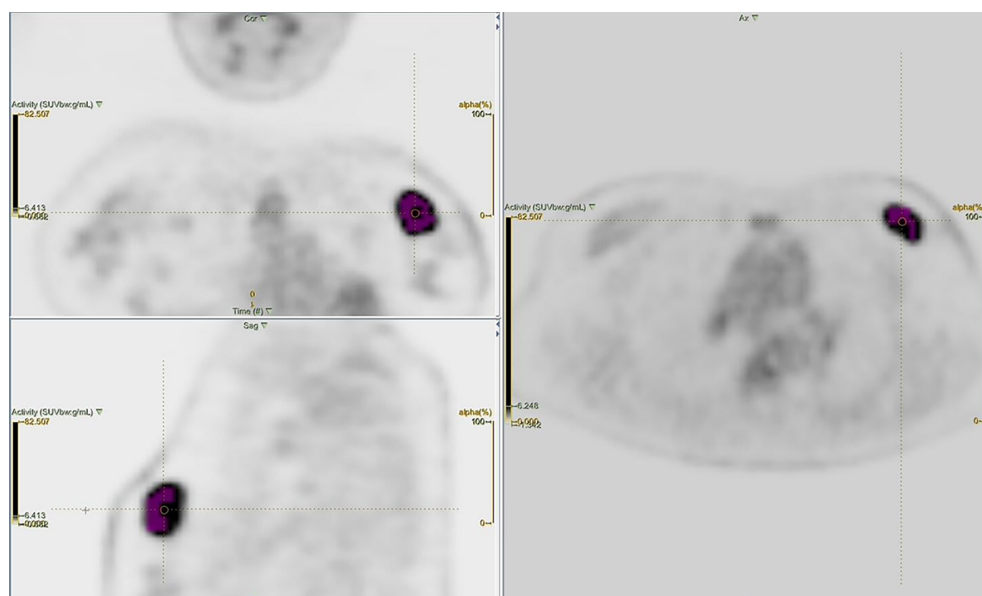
Three-dimensional segmentation of the primary breast lesion using a 40% SUV_{max} in the LIFEx program
